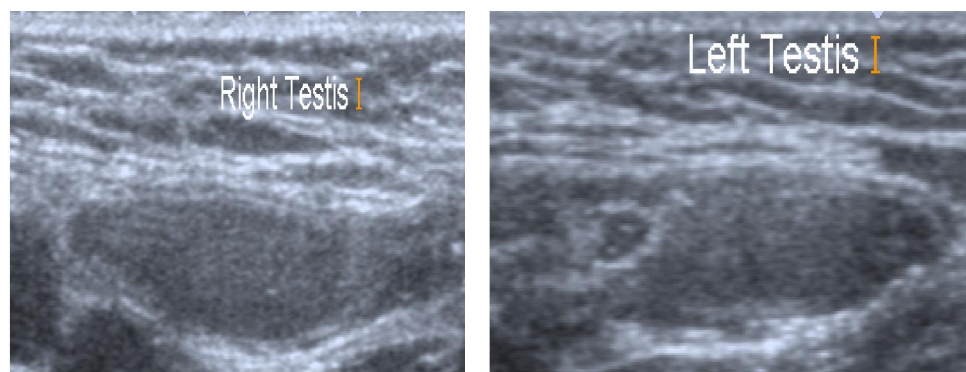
Abdomino-pelvic and scrotal ultrasound revealed bilateral UDT are seen in both inguinal canal.
